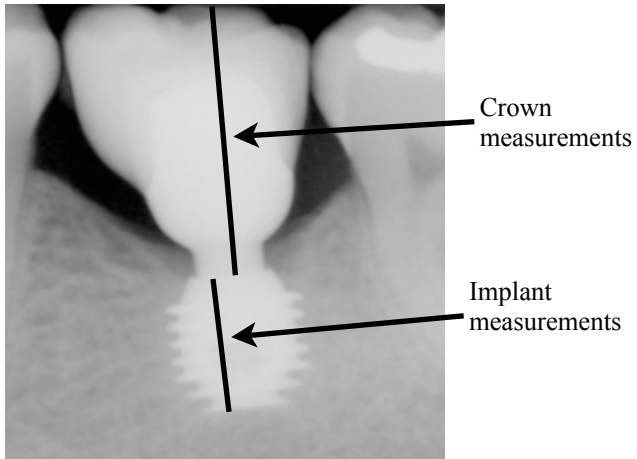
Summary of radiographic measurements.
